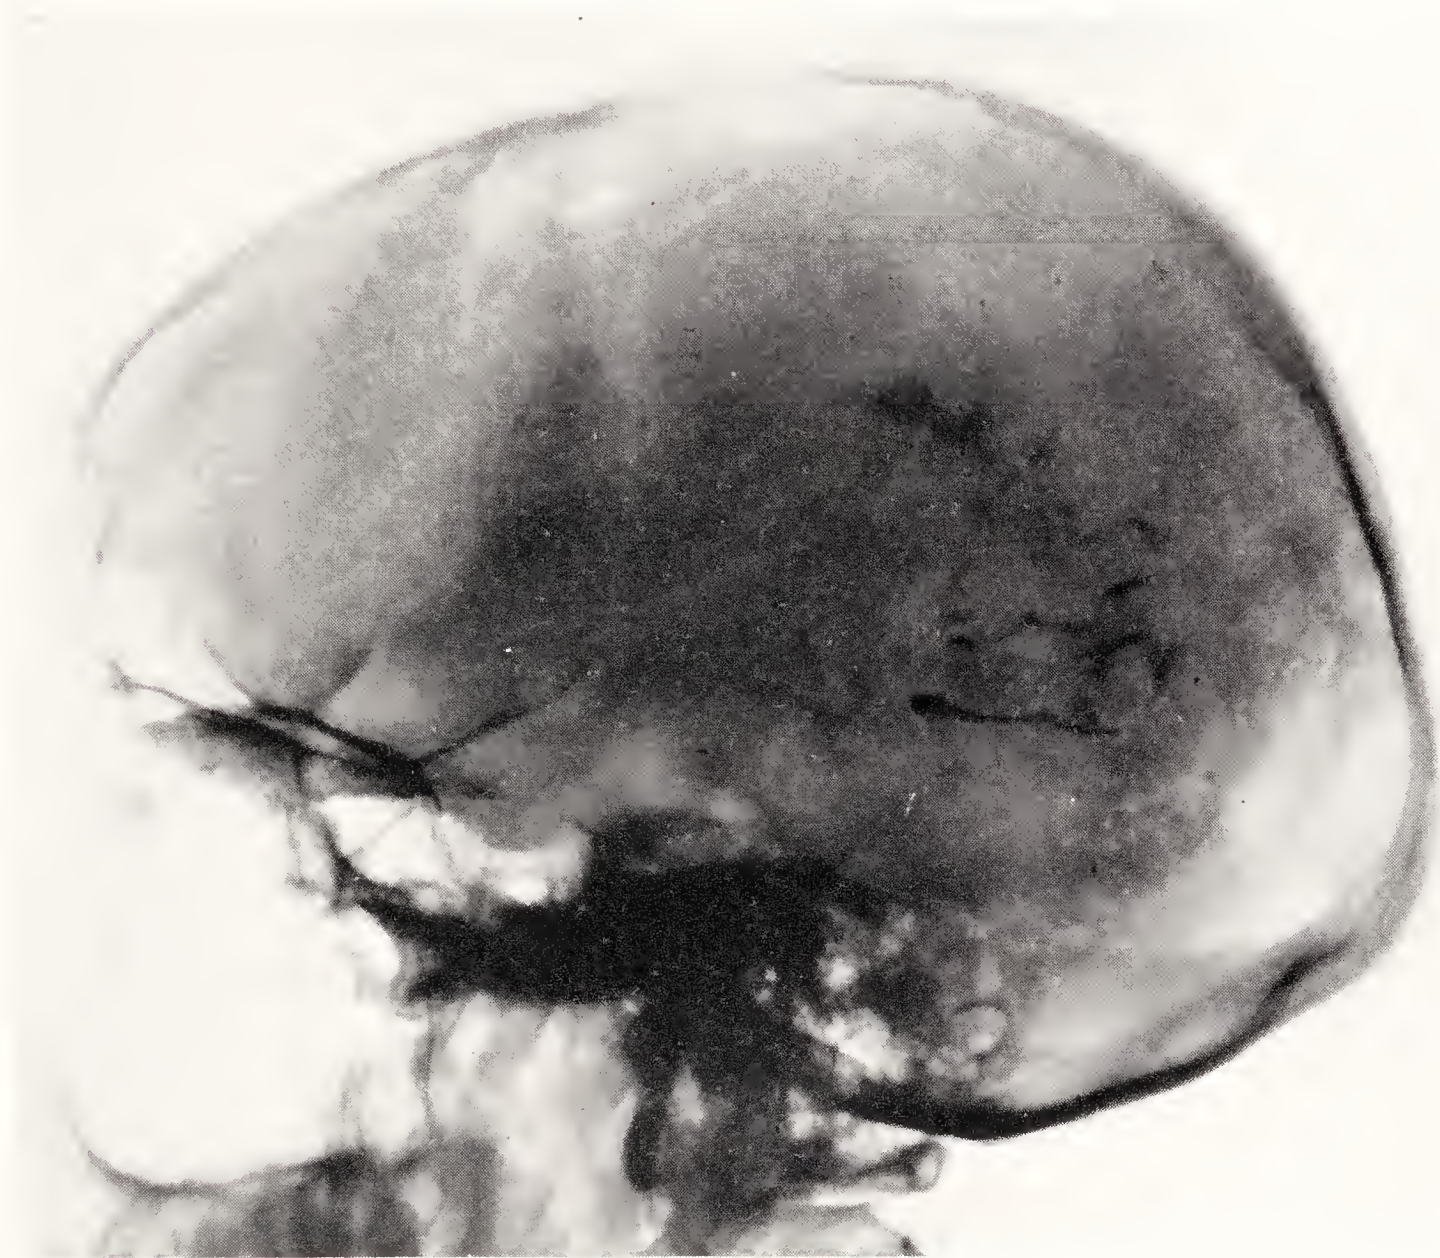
X-ray showing spotty calcification in parieto-occipital region leading to preoperative diagnosis of oligodendroglioma.
